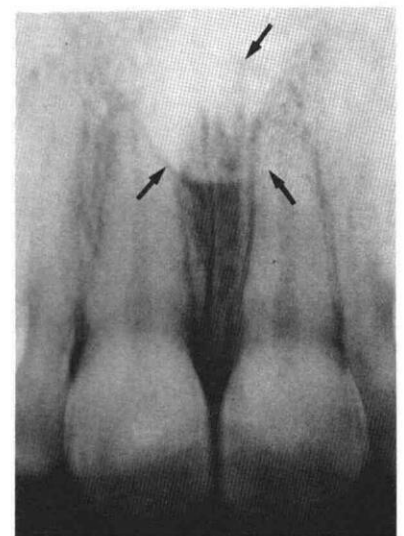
A periapical radiograph of the central incisors showing the presence of a tooth-like structure at the apices. The incisors show normal root formation and an intact periodontium.
